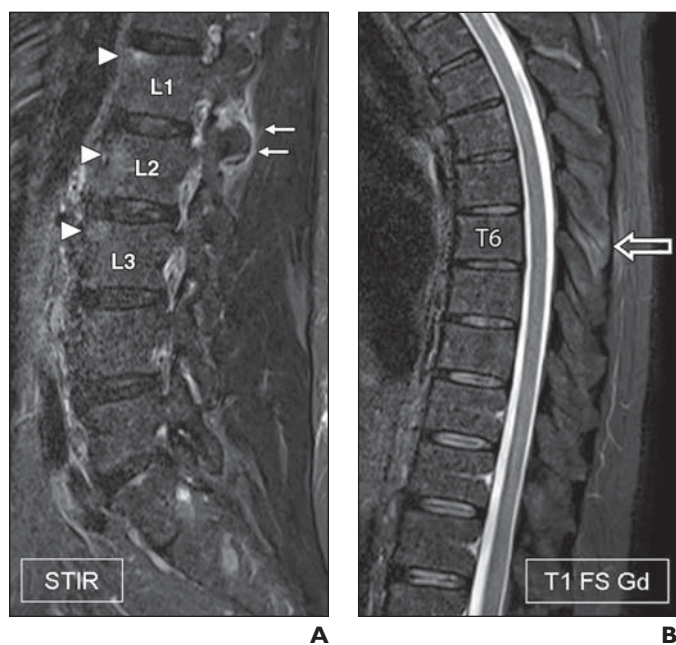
39-year-old man with spondyloarthritis. A and B, Sagittal STIR MR image of lumbar spine (A) and fat-suppressed gadolinium-enhanced T1-weighted MR image of thoracic spine (B) show soft-tissue edema surrounding facet joint of L2 (arrows, A) and enthesitis of T6 spinal process (arrow, B). A also shows anterior spondylitis of L1-L3 (arrowheads).
